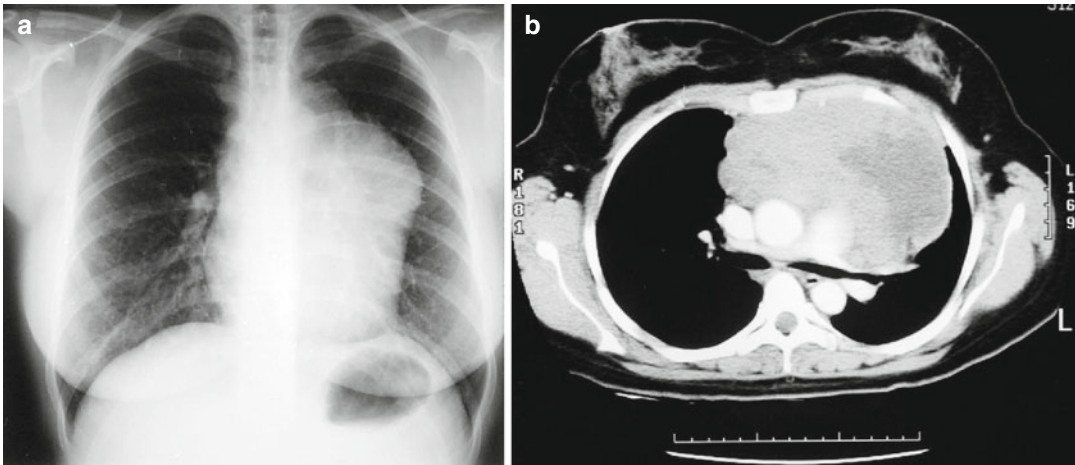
CXR (a) and CT (b) scan from a female patient presenting with PMBCL. Note the large anterior mediastinal mass, with areas suggestive of central necrosis. Marked breast oedema is present
